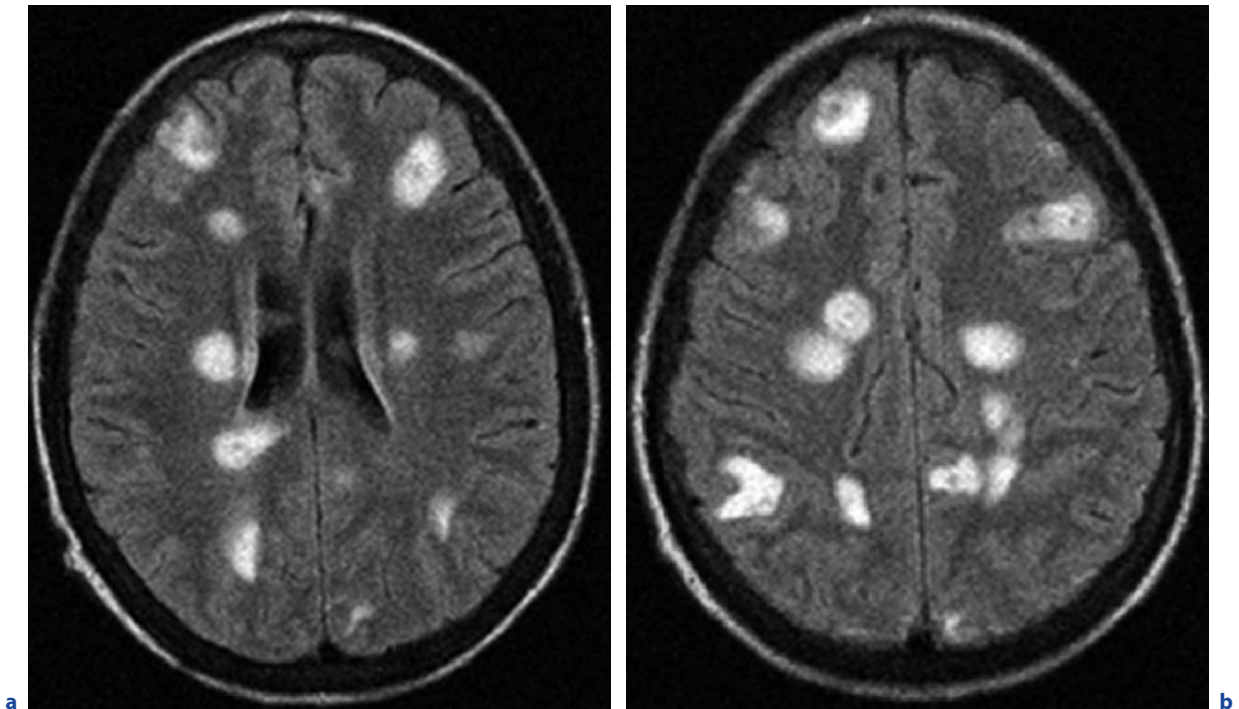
Systemic nocardiosis with CNS involvement in a 16-year-old immunosuppressed boy. a,b Axial FLAIR images. c,d see next page
